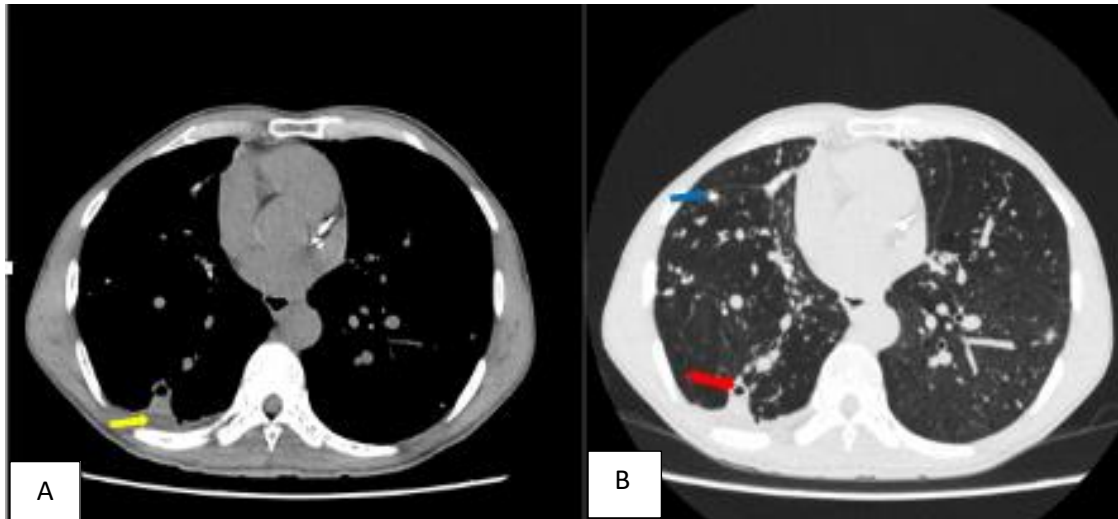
Axial non contrast CT scan, axial mediastinal and lung windows of the chest of third CPA diagnosed at T2, demonstrating A) right lung nodules (blue arrow); B) small right lower lobe cavity with pericavitary infiltration (red arrow) as well as a small pleural effusion (yellow arrow).
